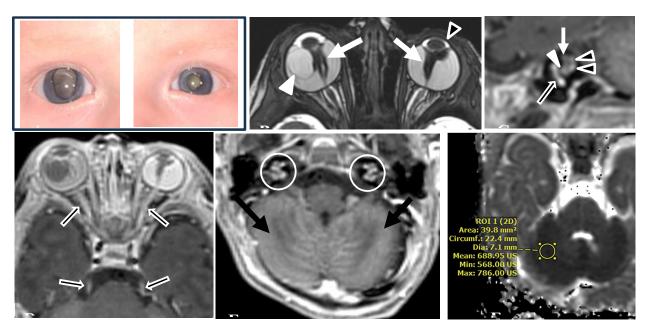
CASE I. MRI examination with and without IV gadolinium in a five-week-old male presenting with bilateral leukocoria. Clinical photograph of the eyes (A) demonstrates bilateral leukocoria. Axial bSSFP image (B) demonstrates bilateral funnel retinal detachments (white arrows). There is a loculated fluid collection in the right posterior segment (arrowhead) with mild buphthalmos of the right eye. The left anterior chamber is dysmorphic and shallow (black arrowhead). Sagittal oblique post-gadolinium T1W fat saturation image (C) of the right internal auditory canal demonstrates enhancement of the facial nerve (white arrow), cochlear nerve (white arrowhead), and vestibular nerves (black arrowheads). The cochlear basilar turn is enhancing (open arrow). These findings were also seen in the left internal auditory canal (not shown). Axial post-gadolinium T1W fat saturation images (D and E) show avid enhancement of the optic nerves, cisternal trigeminal nerves (open arrows in D), cochlea (circles in E), and cerebellum (black arrows in E). ADC map (F) demonstrates diffusion restriction of the cerebellum. All findings persisted on two follow-up MRI examinations, up to three weeks apart.
